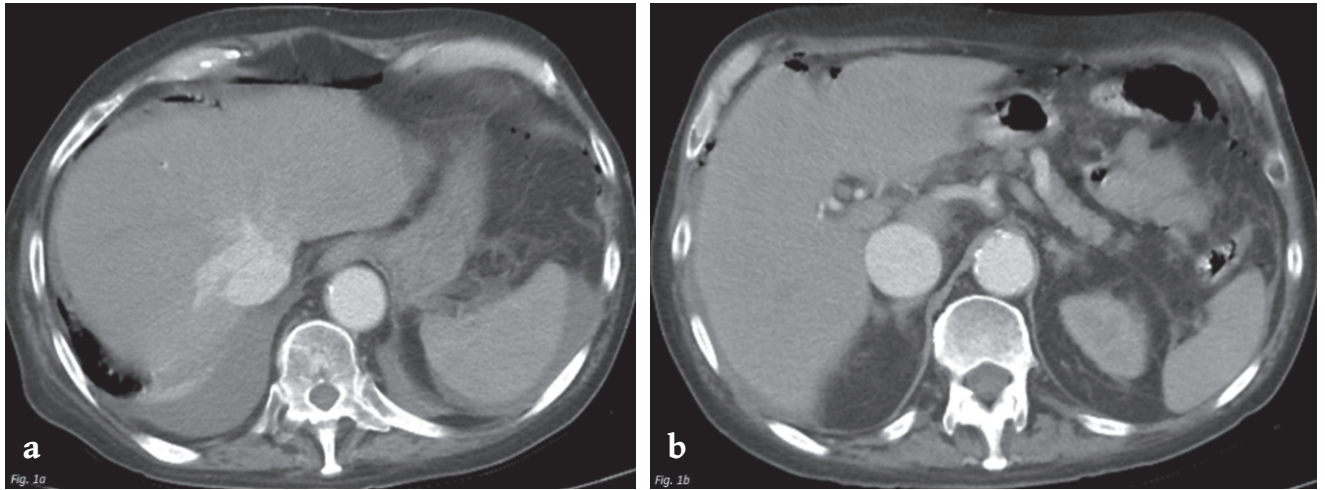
a. Abdominal contrast enhanced CT, arterial phase at the hepatic veins' level, b. Abdominal contrast enhanced CT, arterial phase at the suprarenal level.
